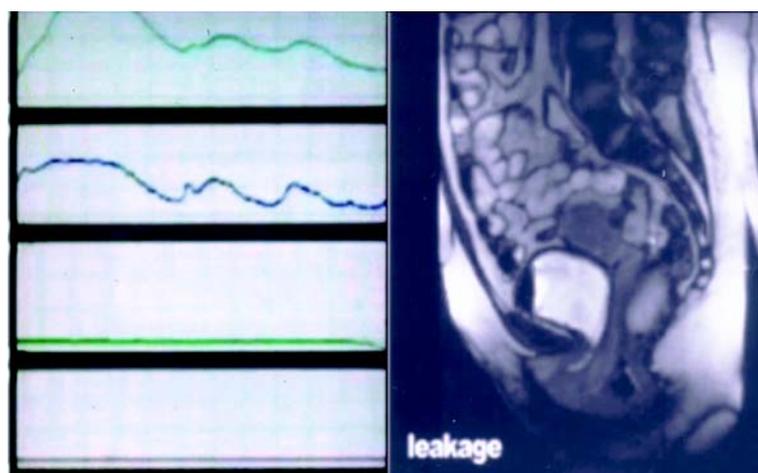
Magnetic resonance imaging video urodynamics. Urodynamic parameters during Valsalva maneuvers concomitant to magnetic resonance image of the pelvis showing descent of the bladder neck below the pucococcygeal line and the urethra fully opened, allowing loss of urine.
